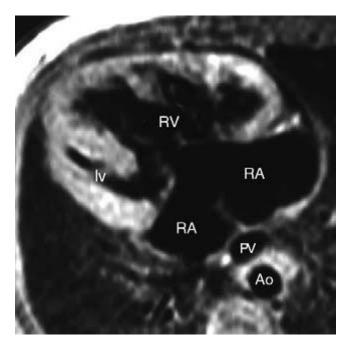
Double-inlet right ventricle in a patient with right isomerism. Axial MR image shows that the whole left-sided right atrium (RA) and more than half of the right-sided right atrium are connected to the anteriorly located main chamber of right ventricular morphology (RV). The rudimentary left ventricle (lv) is located rightward and posterior to the right ventricle. Ao, descending aorta; PV, anomalous pulmonary venous confluence.
